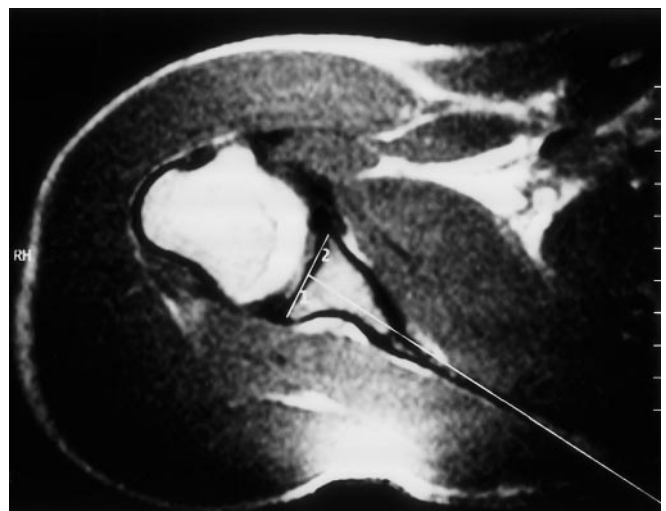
Axial MR image for determining the extent of glenoid version using the method described by Saha in 1978. *Line 1* from the anterior to the posterior point of the glenoid. *Line 2* from the middle of line 1 to the medial border of the glenoid. The retroversion angle is the angle between *line 1* and *line 2*
